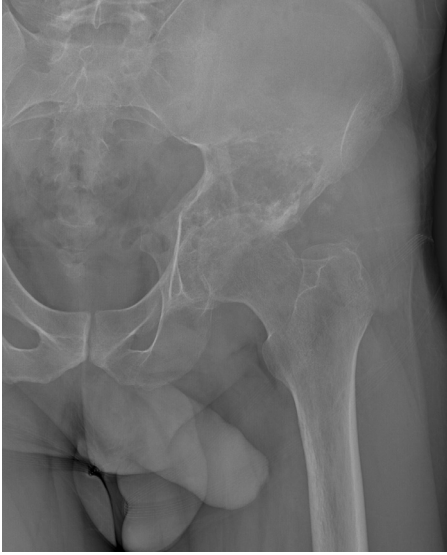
X-rays demonstrates an expansile lytic process involving the acetabular region of the left hip.
